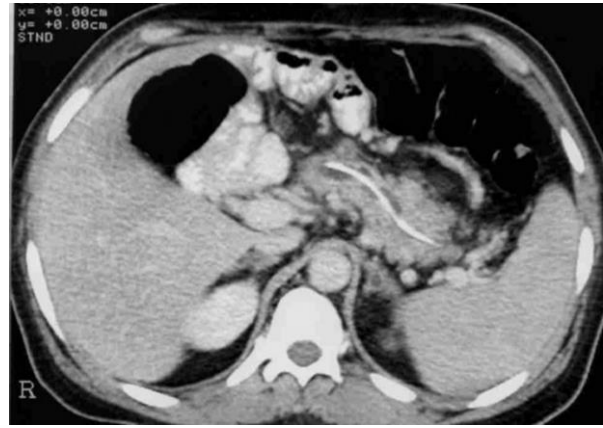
Postoperative CT after PD: pancreatic drain
